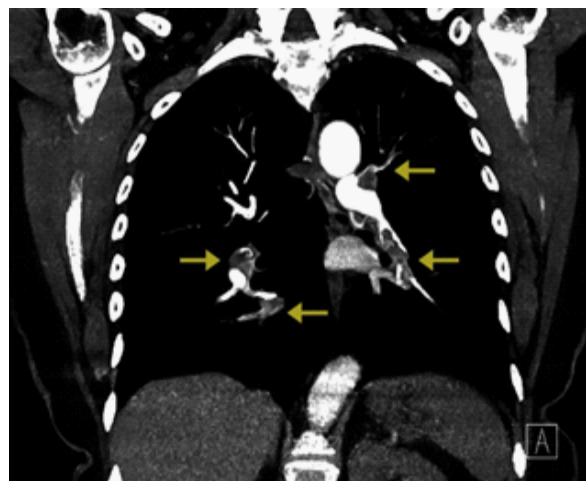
CT-Angiography of the chest showing multiple filling defects (arrows).
